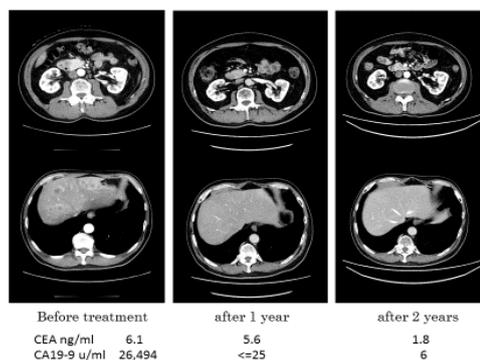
CT findings of the pancreas, liver and the tumour marker for two years in case 1
